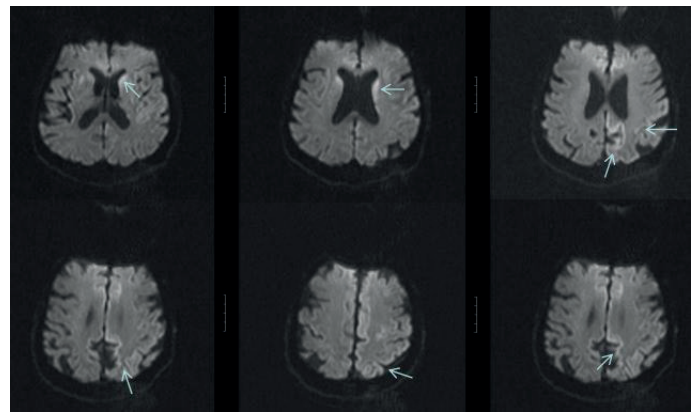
DWI performed two weeks after FDG-PET shows increased signal intensity in caudat nucleus, putamen and cortical regions (arrows).
